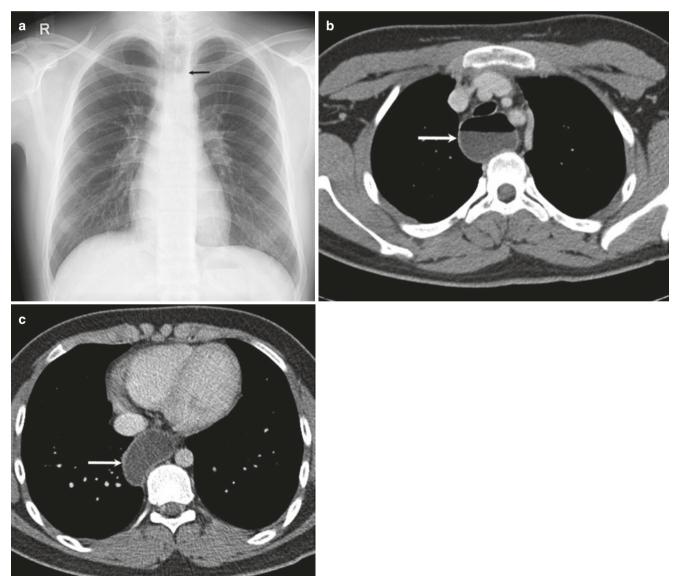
21-year-old man with recurrent chest pain due to achalasia cardia. (a) Frontal radiograph shows an air-fluid level in the central upper mediastinum (arrow) superimposed on the tracheal lucency. (b, c) Axial CT images reveal a dilated esophagus (arrows) throughout its course
